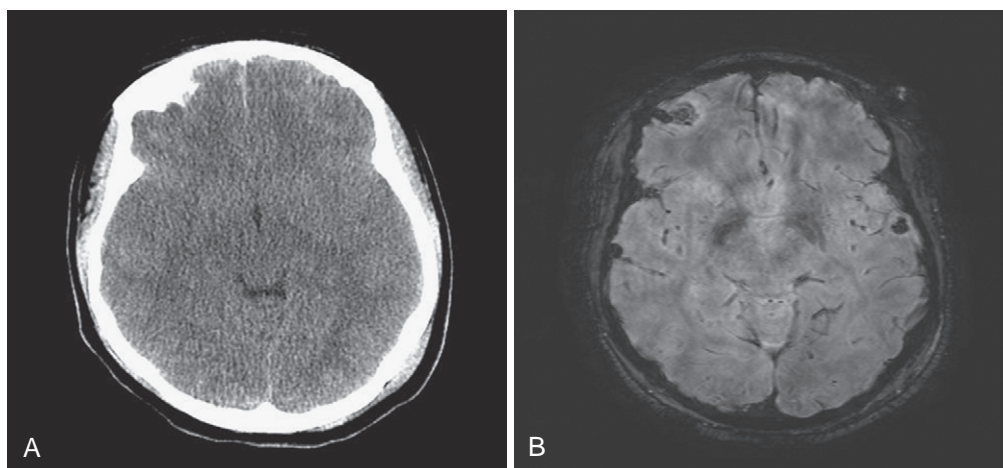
The importance of imaging in mild traumatic brain injury. Patients with apparently normal consciousness at presentation can suffer widespread cerebral damage when subjected to mechanisms that cause diffuse axonal injury. Cognitive disturbances and neurologic symptoms are common in these patients. A, Unenhanced computed tomography scan of conscious patient (GCS 15) showing subarachnoid hemorrhage. B, Susceptibility-weighted gradient echo magnetic resonance image (MRI) showing widespread parenchymal hemorrhages characteristic of diffuse axonal injury. (Courtesy Jill Hunter, MD.)
